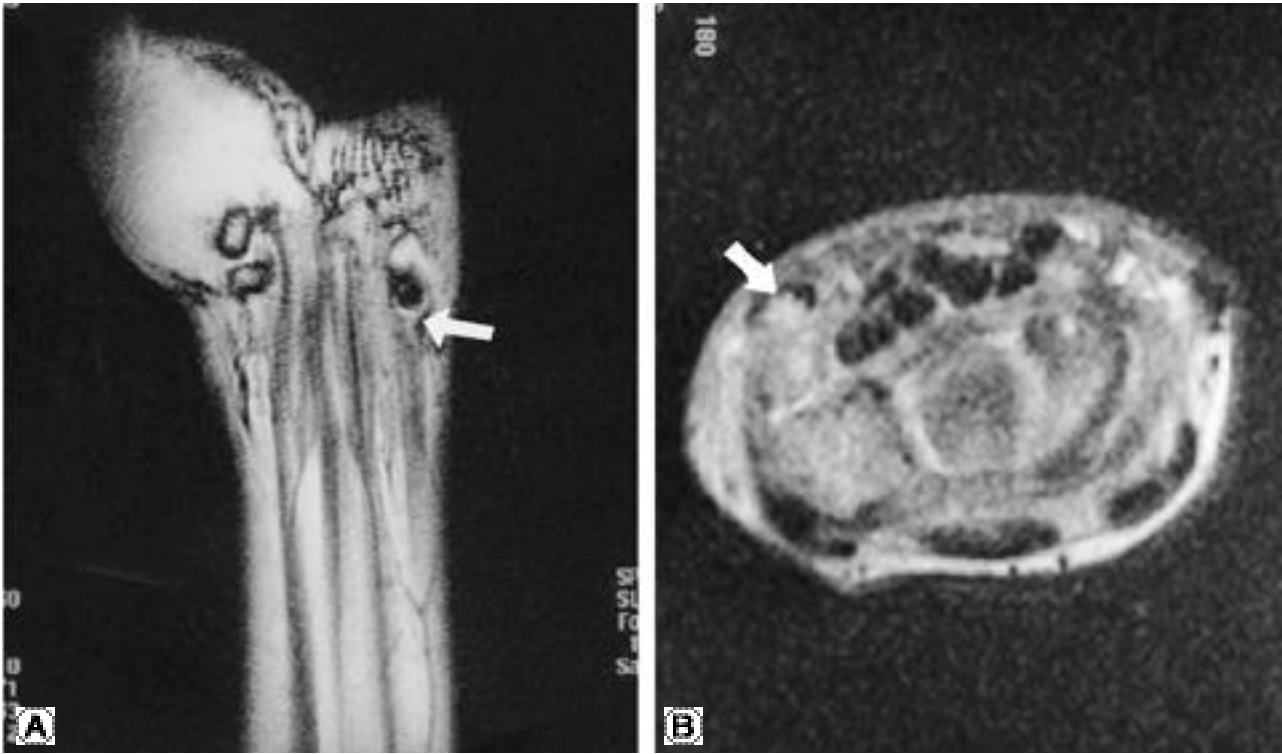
MRI of left wrist, It shows high signal intensity below flexor carpi ulnaris that means tendinitis of flexor carpi ulnaris (arrow)
